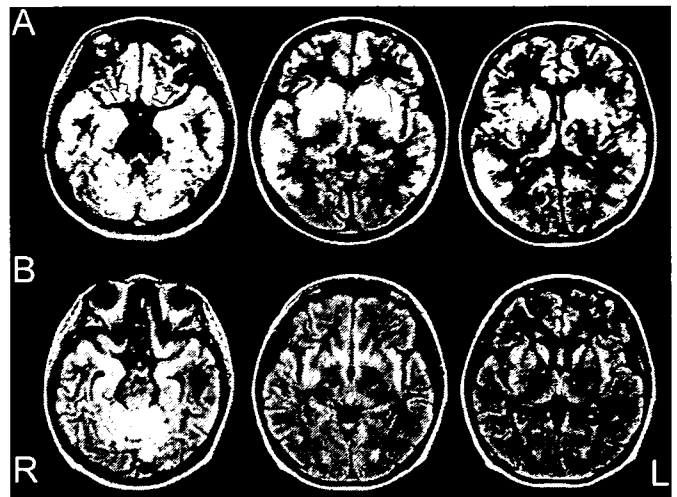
(A) Axial fluid-attenuated inversion recovery (FLAIR) MRI done 17 days after the first admission to the general hospital shows bilateral high signal intensity in the basal ganglia, as well as in the medial temporal lobes. Arrows indicate medial temporal lobes. (B) MRI after corticosteroid treatment. Axial FLAIR MRI done 45 days after the first admission shows marked resolution of the temporal lobe and basal ganglia signal abnormalities.
